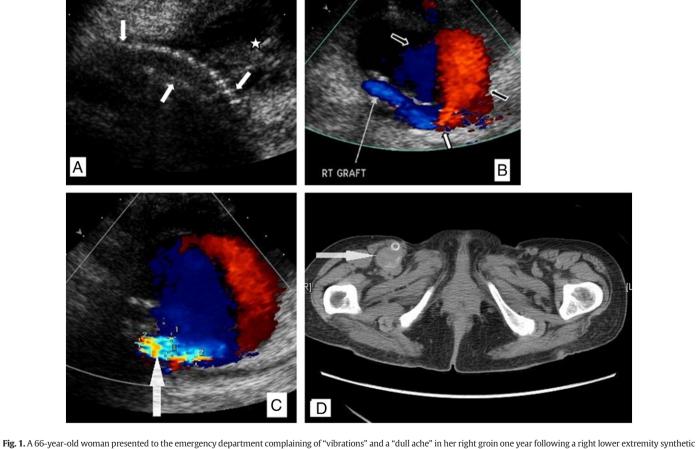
A 66-year-old woman presented to the emergency department complaining of "vibrations" and a "dull ache" in her right groin one year following a right lower extremity synthetic arterial bypass graft between the common femoral artery (CFA) and poplical artery. A Right groin ultrasound demonstrated a tubular structure (between white arrows), consistent with a synthetic arterial bypass graft between the common femoral artery (CFA) and poplical artery. A Right groin ultrasound demonstrated a tubular structure (between white arrows), consistent with a synthetic arterial bypass graft, that demonstrated good flow on additional images (not shown). B. An ill-defined heterogeneous area (star, A) was noted at the origin of the graft (RT GRAFT) near the CFA. Color Doppler imaging showed blood entering a pseudoaneurysm (PSA) at the anastomosis of the graft (solid white arrow) and CFA. The long white arrow indicates the graft and two open white arrows indicate the PSA sac. C. The classic swirling pattern ("yin-yang") indicates turbulent flow as blood enters the PSA sac, coming towards the transducer (red) and then turning away from the transducer (blue) to exit into the graft. This image provides a sagittal cut through the neck of the PSA (white arrow) and an axial cut through the PSA sac. D. CT in the axial plane corroborated CDUS findings (white arrow).
